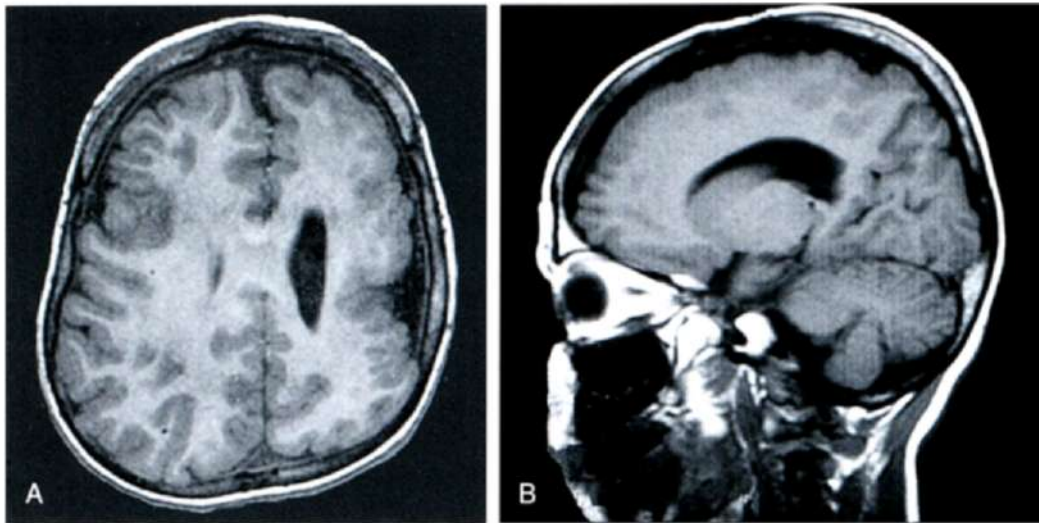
A, Axial T1-weighted MR image showing a polymicrogyric cortex on most of the left hemisphere with an accentuation in the centro-parietal region. Note the clustering of small gyri around an atrophic region. B, Sagittal T1-weighted MR image of the same patient. Note the extensive malformation which, in the more posterior frontal regions, has the appearance of an almost smooth (pachygyric) cortex. A few individualized small gyri can be seen in the frontal pole.
